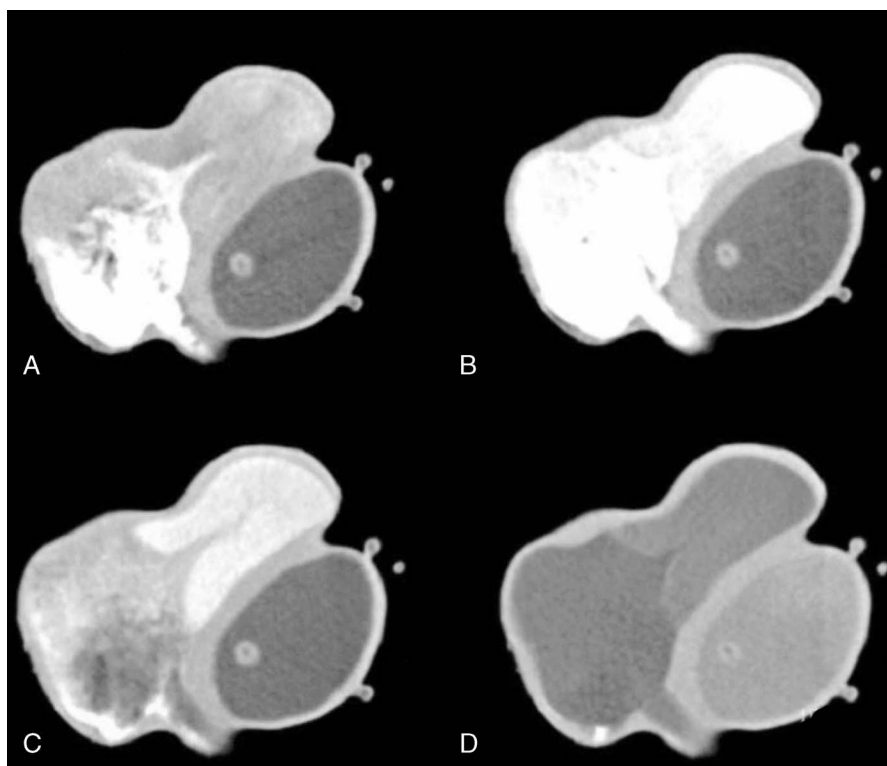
Computed tomography images of dynamic contrast material transport through the heart chambers, depicting nonhomogeneously mixed contrast in the right ventricle (A and B), mixing action of the pulmonary valve (C), and more evenly distributed contrast material in the left heart upon pulmonary return (D).
